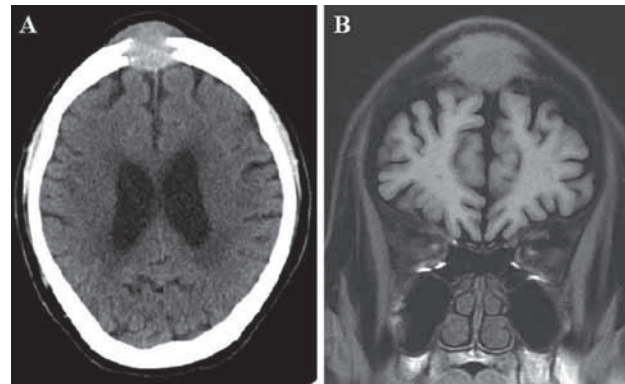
(A) Contrast-enhanced CT of brain showed a soft tissue mass, $4.1 \times 3.6 \times 2.3$ cm in size, with bony destruction on midline anterior frontal region. (B) Coronal T1-weighted magnetic resonance image demonstrated a destructive tumor on the midline frontal bone with invasion of the scalp and dura matter.
